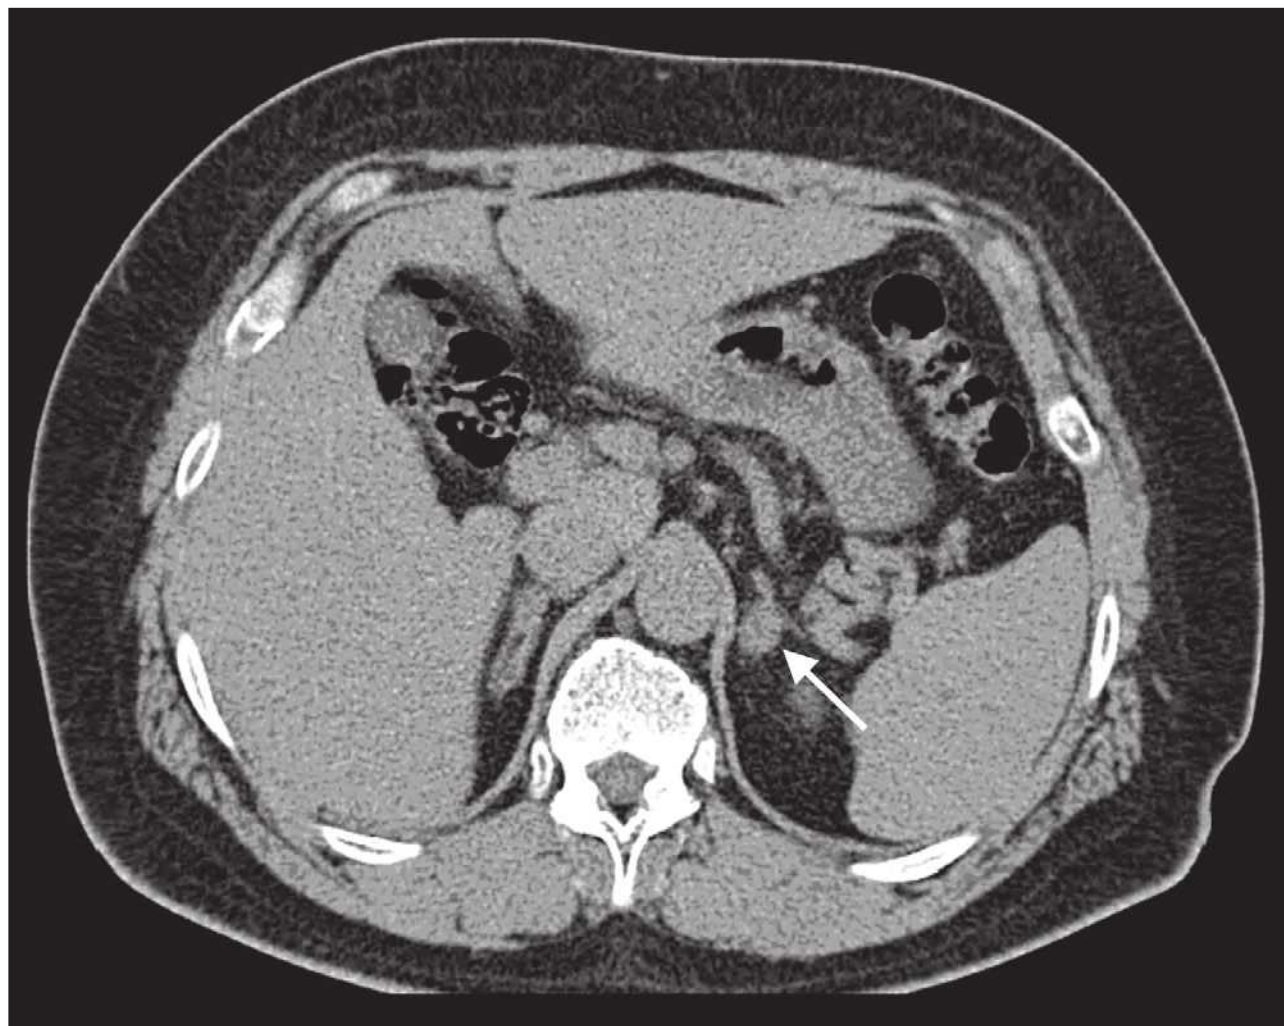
A 1.5 cm left adrenal adenoma (*arrow*) in the non-contrast enhanced computed tomography examination. The mass has an attenuation value <10 H and a calculated washout rate $>50\%$. These are radiologic features consistent with an adenoma. Adrenal venous sampling (results shown in Table 43.1) provided evidence of a unilateral, left aldosterone-producing tumor.
